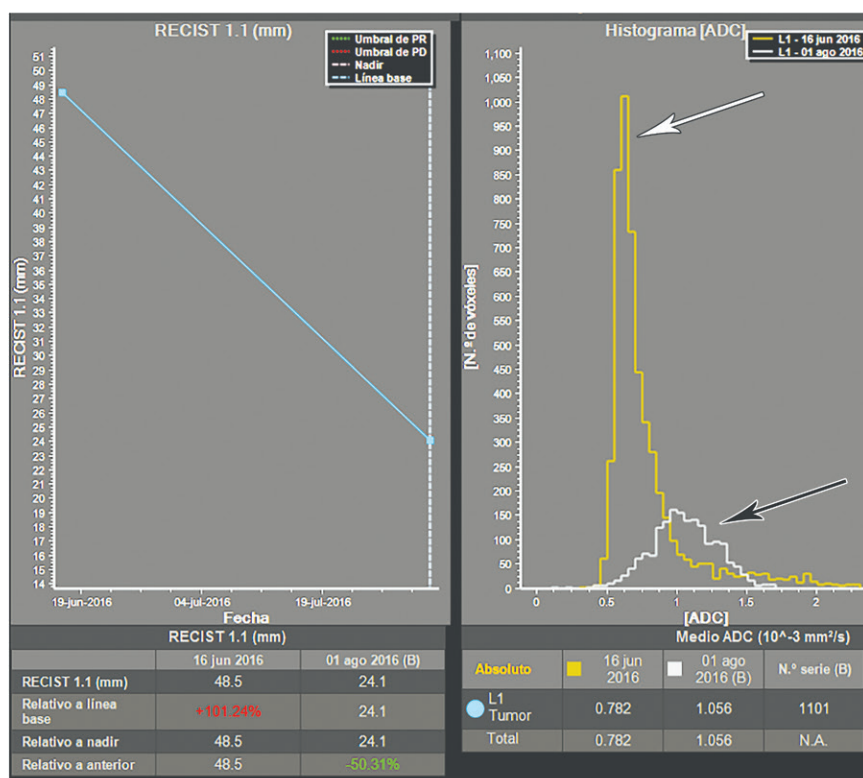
Alveolar rhabdomyosarcoma in an 11-year-old boy with a left thigh mass. (a) Axial fat-suppressed T2-weighted image shows a lobulated heterogeneously hyperintense lesion (*) with a peripheral cystic or necrotic component (arrow) involving the biceps femoris muscle. (b) DCE image shows diffuse early enhancement of the tumor (black arrow). This finding correlates with a type III or IV TIC profile (white arrow). Blue curve = reference standard of arterial uptake. (c) Axial diffusion-weighted image and ADC image show restricted diffusion in the mass (*). (d) Axial contrast-enhanced fat-suppressed T1-weighted image after chemotherapy shows significant shrinkage of the tumor (*), with persistence of heterogeneous enhancement. (e) Graphs from volumetric determination of ADC show ADC of $0.78 \times 10^{-3} \text{ mm}^2/\text{sec}$ with a high and sharp ADC histogram before treatment (white arrow). ADC after 2 months of treatment was $1.06 \times 10^{-3} \text{ mm}^2/\text{sec}$ with a short and wide ADC histogram with rightward shift (black arrow). There was 50% reduction of tumor volume in the interval.
